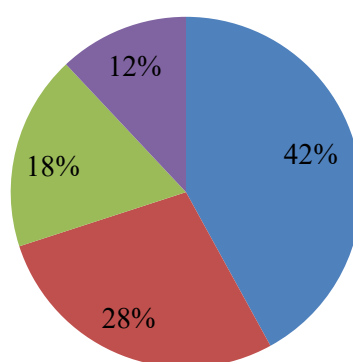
Distribution of mandibular third molars according to radiographic angulation
